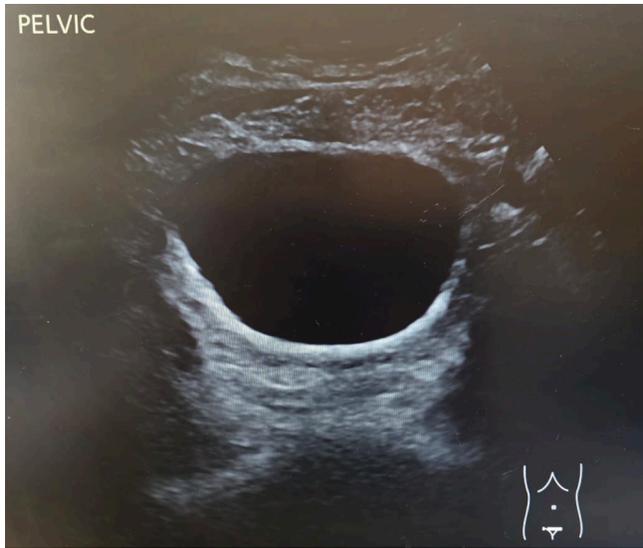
Ultrasound pelvis of a 24-year-old female showing absent uterus and both ovaries
